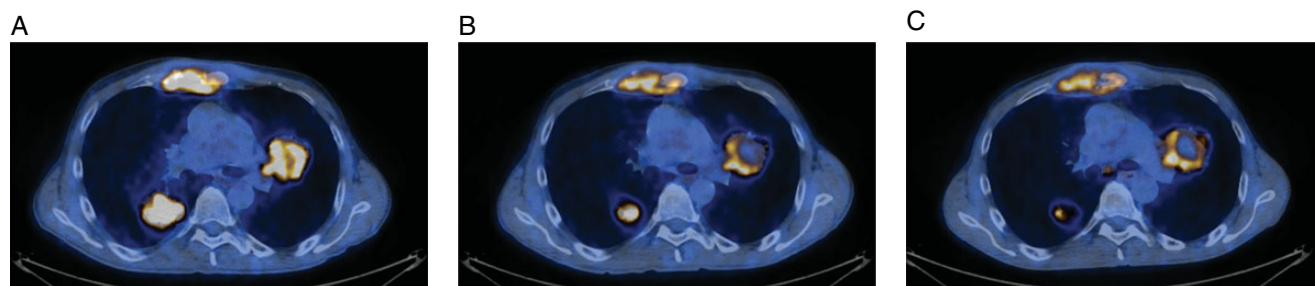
Positron emission tomography/computed tomography scans at baseline (A), after 8 weeks of treatment (B), after 5 months of treatment (C).
